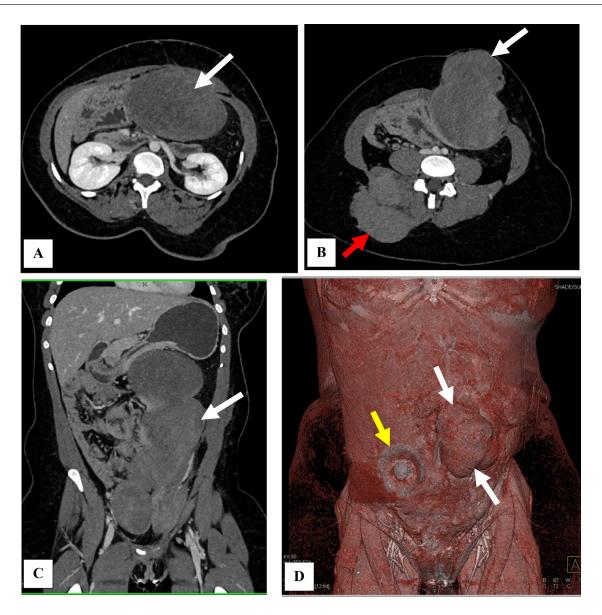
A 33-year-old female with a history of FAP and multiple desmoid tumors. (A-C) A large subcutaneous and intramuscular lesion within the left abdominal wall, extending vertically down the left abdomen seen in both axial and coronal CT scans, measuring approximately 12.5 cm x 11.1 cm in the largest diameter, exerting mass effect on nearby structures (white arrow). Another large lesion in the paraspinal region measuring 7.7 x 4.3 cm (red arrow). They are likely to be desmoid tumors, consistent with the patient's history. D: 3-dimensional volume rendering showing in detail the growth and extent of a large desmoid tumor in the left abdominal wall (white arrow). An ileostomy stoma can be seen on the right side (yellow arrow) as the patient underwent proctocolectomy and diverting ileostomy for FAP.
